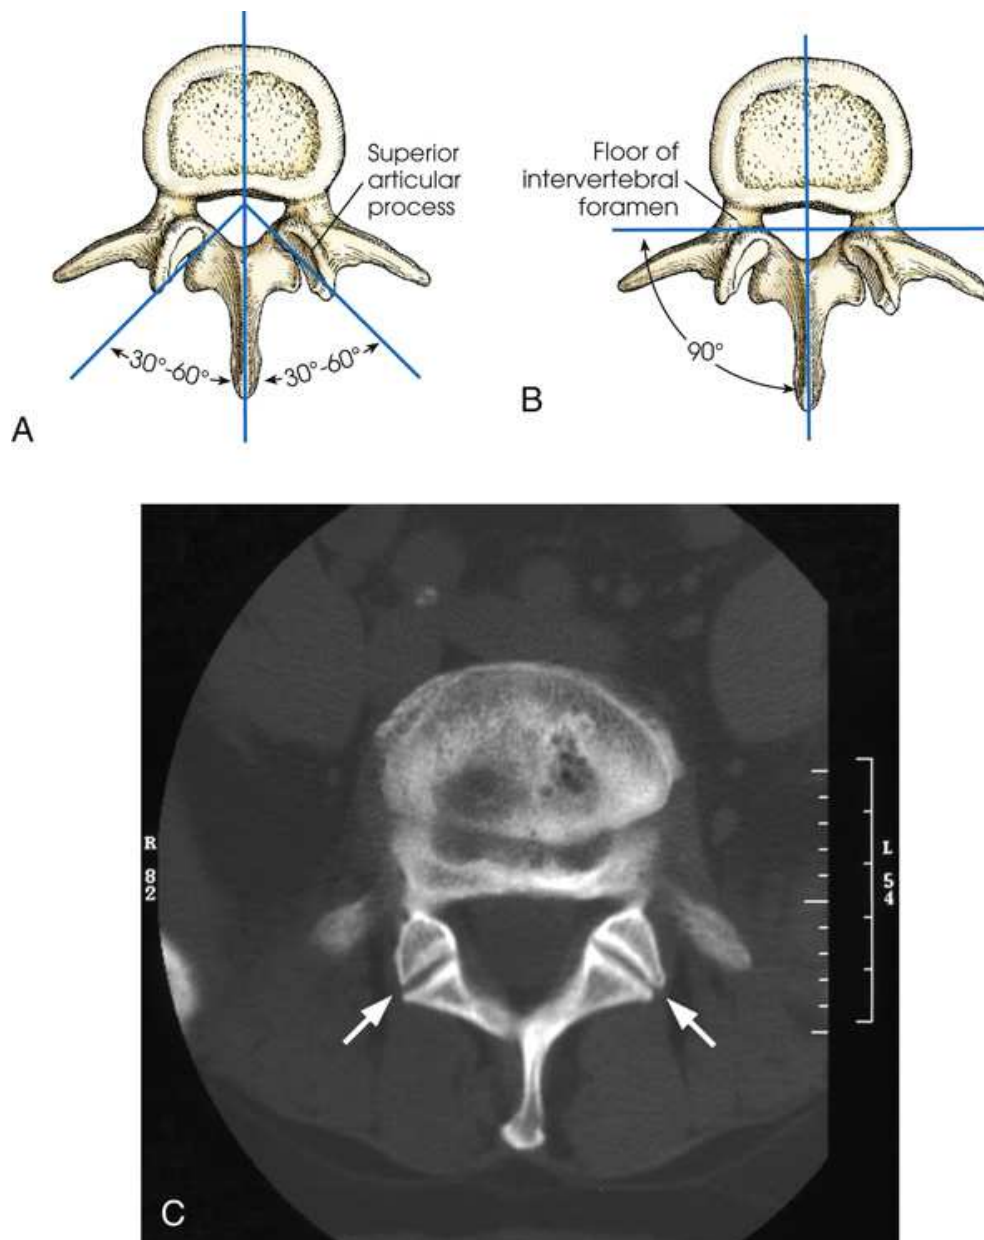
(A) Direction of lumbar zygapophyseal joints. (B) Superior aspect showing orientation of lumbar intervertebral foramina. (C) Axial CT image of lumbar spine showing angles of zygapophyseal joints (arrows).
